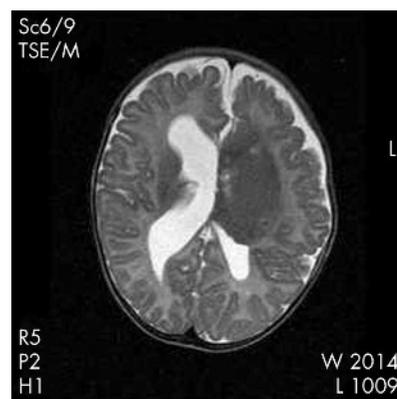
Postnatal MRI scan. Axial T2 weighted sequence, showing large mass lesion involving the body and frontal horn of the left lateral ventricle. Within the body of the right ventricle was a solitary subependymal nodule.
